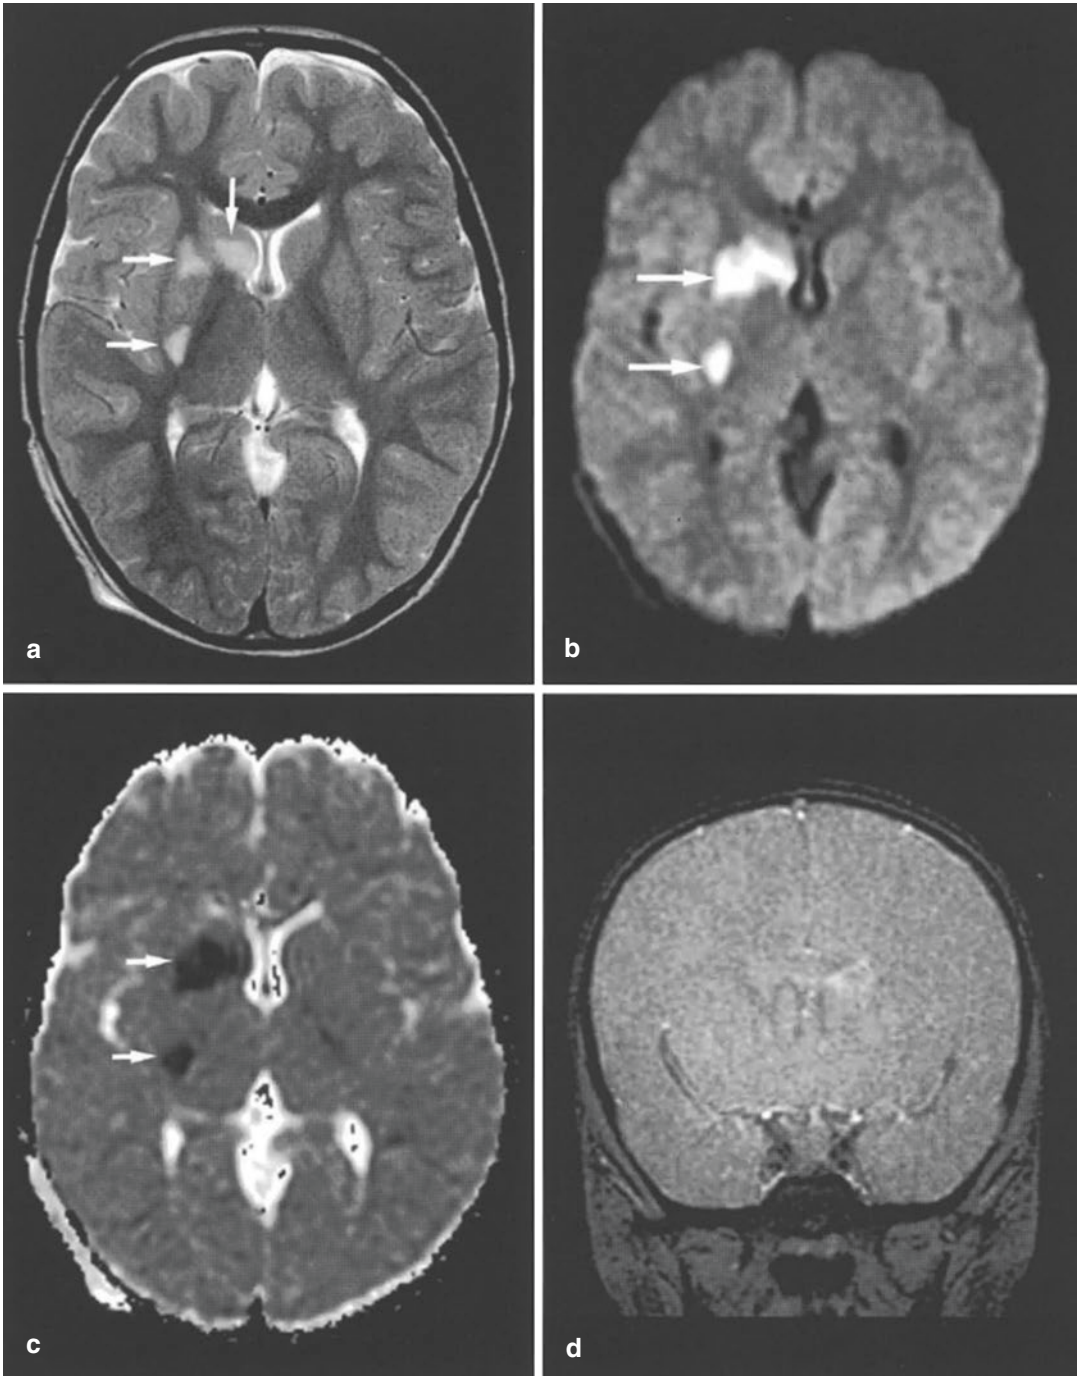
(a–d) Diffuse axonal injury in the basal ganglia in a 3-year-old boy after a motor vehicle accident. (a) T2-weighted image shows hyperintense lesions in the right lentiform and caudate nucleus (*arrows*). (b, c) DW
